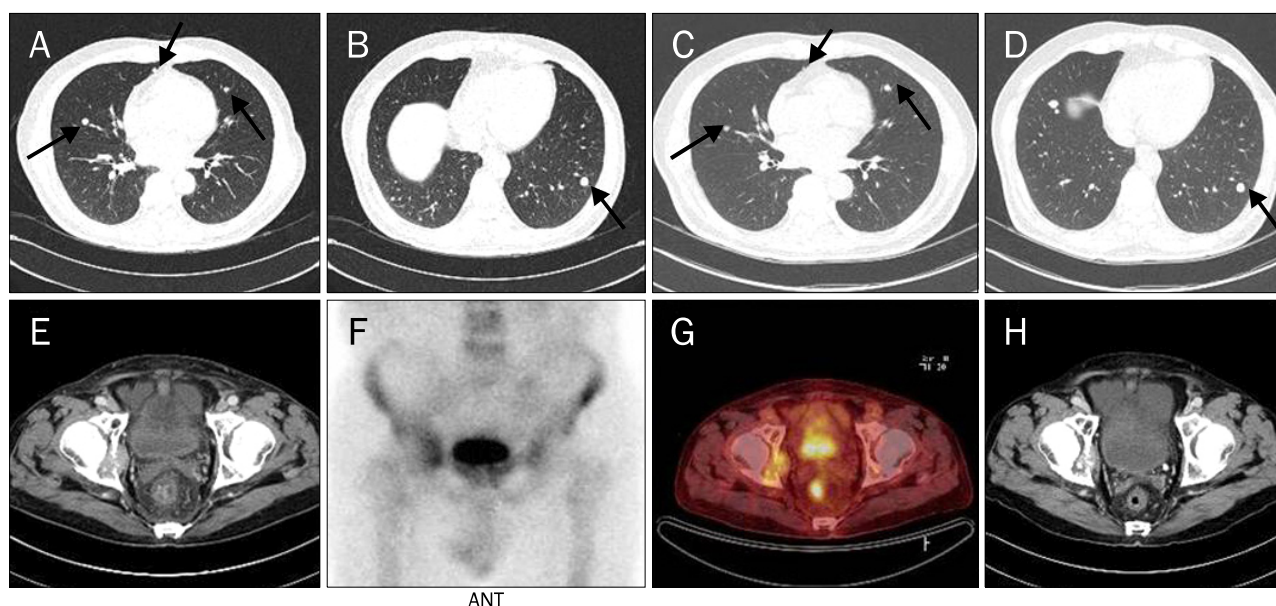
(A-D) The radiologic features of Case 3. (A, B) Chest CT showed variable sized multiple nodules on both lungs (largest, 12 mm) (arrows) before sorafenib treatment. (C, D) Five months after sorafenib administration, chest CT revealed that several variable sized multiple nodules on both lungs had decreased and some nodules remained (arrows). (E-H) The radiologic features of Case 4. (E) Abdomen CT showed an enhancing mass (4.0×2.9 cm) at the right acetabulum. (F, G) Bone scan and PET-CT also showed bone metastasis in the right pelvic bone. (H) Three month after sorafenib administration, abdomen CT showed interval decrease in the size of metastasis at the right acetabulum.
